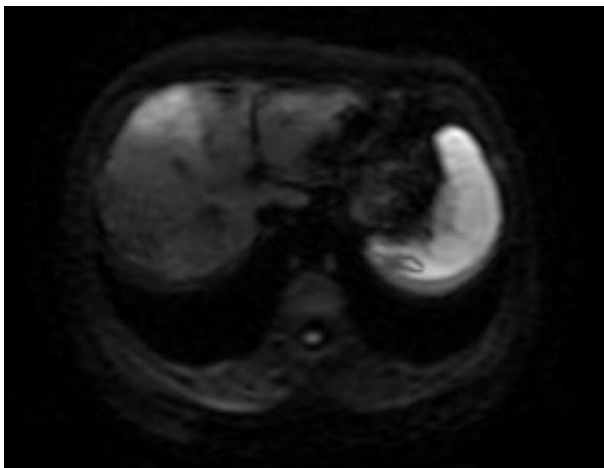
Contrast enhanced T1-weighted image shows the hyperintensity of the mass in right lobe.
